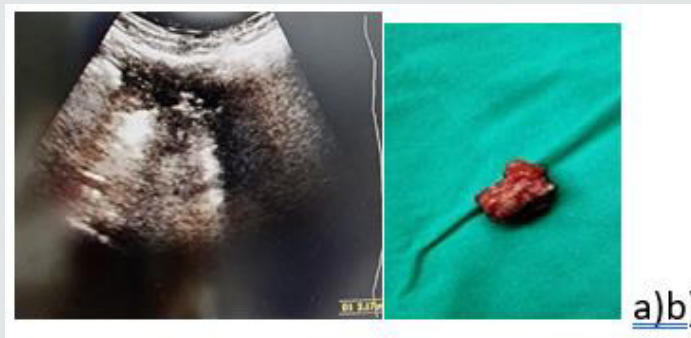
Pelvic and abdominal ultrasound showed a 3 cm × 3 cm × cm, oval-shaped heterogeneous mass within the right rectus abdominus muscle, with no abnormalities of the uterus and ovaries Partly cystic and partly solid intramuscular lesion in the abdominal wall.
